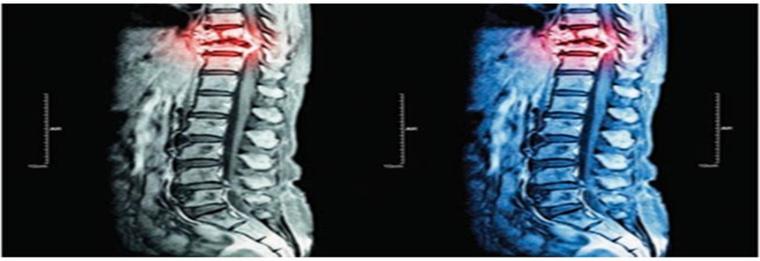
Spinal metastasis. MRI of the thoracic and lumbar spine showing cancer in the thoracic region with spinal compression. (stockdevil/Fotolia) Figure 20.6 X-ray technician in a lead apron prepares to take an x-ray of a patient. This apron is a protective shield of lead and rubber worn by a patient or those taking x-rays to protect the genitals and other vital organs from excessive exposure to x-rays.
